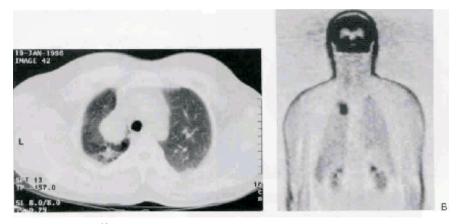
Increased uptake of*¹⁸*FDG in a lung cancer.*
